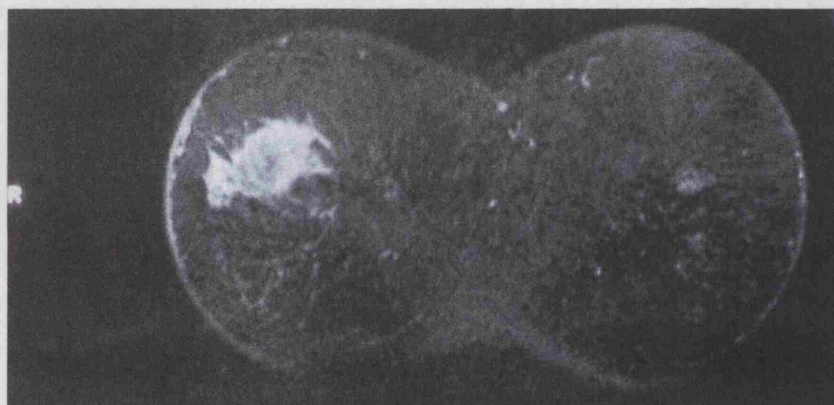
A subtracted MRI image highlighting the tumour in the right breast.
